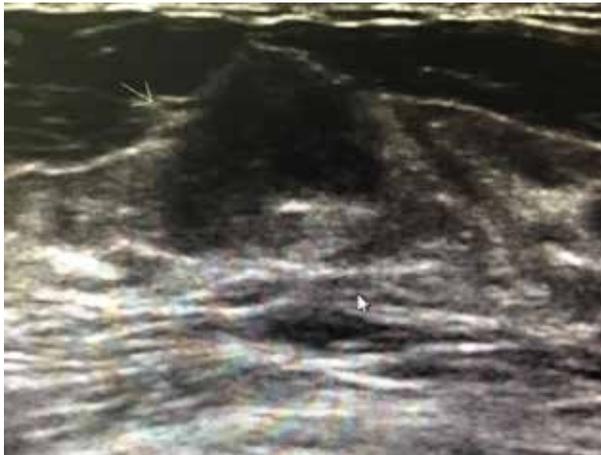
PASH in left breast ultrasound forming an oval mass 1.6X1 cm with no acoustic shadow (Case 1)
